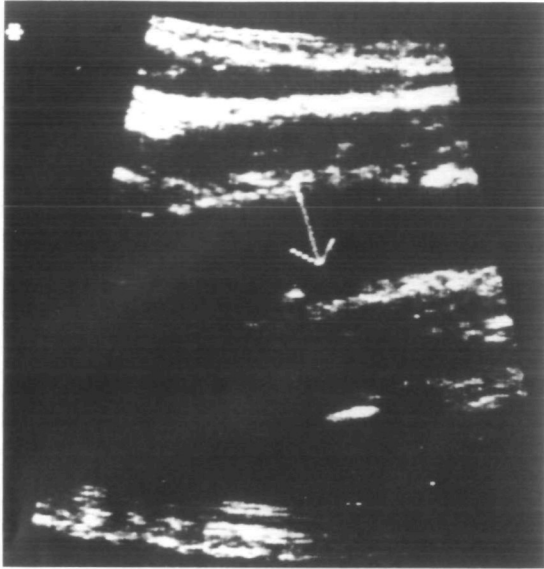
Duplex sonographic evaluation of the right carotid bifurcation demonstrating a small echogenic plaque with a possible ulceration (arrow).
